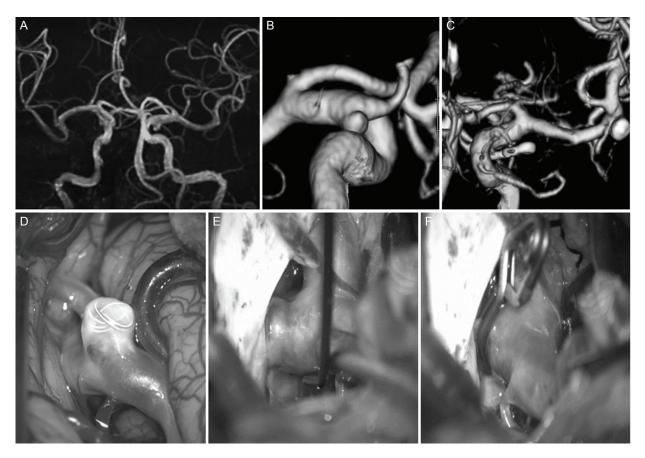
Case 5. (A) Magnetic resonance angiography (MRA) demonstrated no recurrence of left middle cerebral artery (MCA) aneurysm after coil embolization and a de novo left internal carotid artery-posterior communicating artery (IC-PC) aneurysm. (B) Three-dimensional computed tomographic angiography (3D-CTA) demonstrated a left IC-PC broad neck aneurysm. (C) Postoperative 3D-CTA confirmed no recurrence of left MCA aneurysm and complete clipping. (D) Intraoperative photographs of the MCA aneurysm 12 years after coil embolization confirmed no recurrence of left MCA aneurysm. (E-F), Intraoperative photographs of the IC-PC aneurysm before (E) and after (F) clipping.
